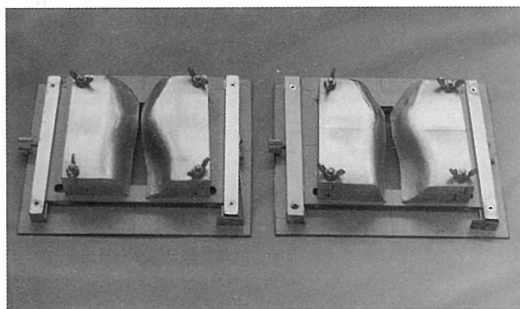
The compensating filter is compensated a ratio of 1:1 in X-ray exposure difference on imaging plate between the mediastinum and the lung field.
